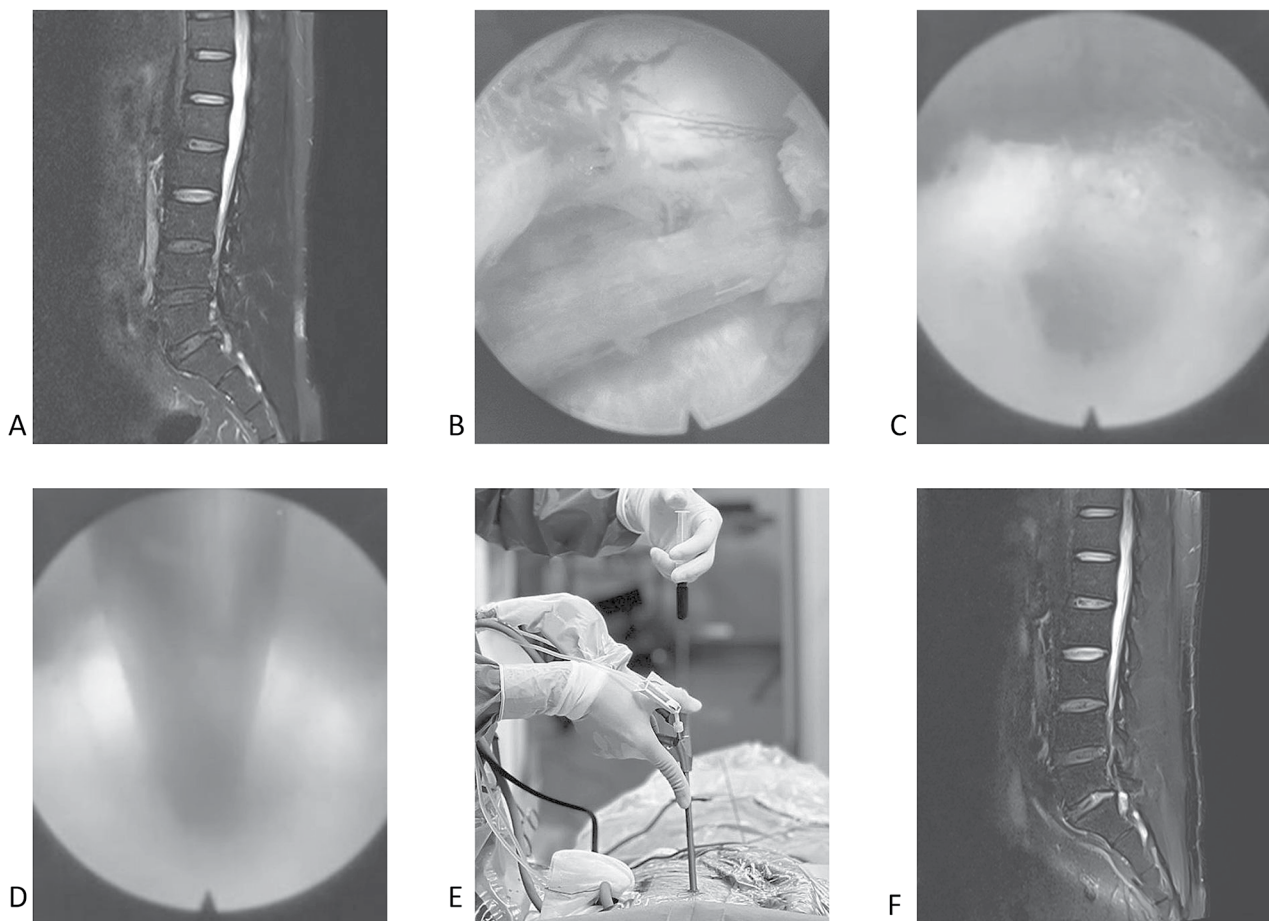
Images of Posterior Endoscopic Nucleotomy Combined with PRP Gel Injection into the Disc. (A) Preoperative MRI. (B) Intraoperative Endoscopic View of Nerve Root. (C) Gelatin Sponge at Annulus Fibrosus Rupture Site. (D) Injection Needle Entering the Disc. (E) PRP Injection. (F) MRI 9 Months Postoperatively
